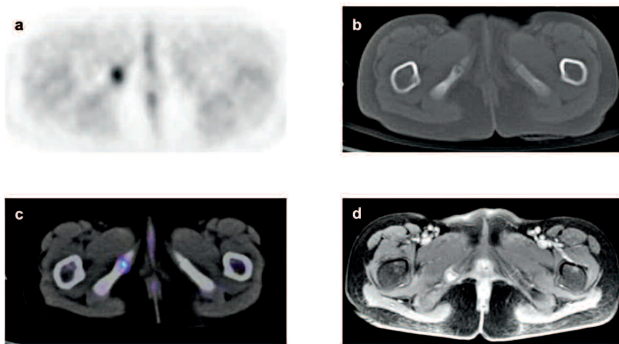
^{18}F -FDG PET image shows focal uptake (a), which corresponds to the radiolucent structure in the right inferior ischial ramus on CT (b). ^{18}F -FDG PET/CT fusion image (c) confirms the findings shown above. MRI (d) shows contrast enhancement of the structure.
